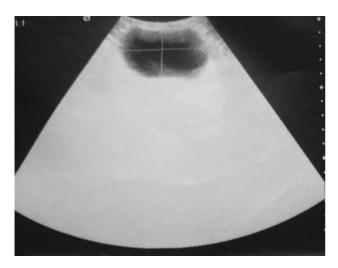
An oblique sonograpic section obtained from just over the inguinal swelling depicting the anechoic internal structure of the paraovarian cyst contained in the sac. Other associated structures such as the ovary and fallopian tube are indiscernible. Note the close proximity of cystic structure to the overlying skin with little space between convexity of the probe and cyst
